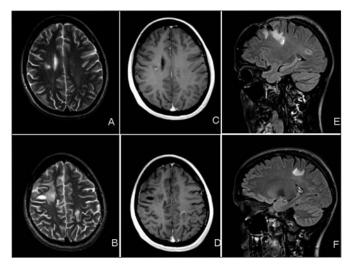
Brain MRI; A) and B) T2-wighted images; C) and D) T1weighted sequences following gadolinium application; E) and F) FLAIR images; Comparing to previous MRI (see reference 1) two new lesions are seen, one in the white matter of the right frontal lobe, and other in subcortical white matter of the left postcentral region. Both lesions are showing irregular rim enhancement after application of the contrast medium. Previously present cystic lesions are significantly smaller and paler.
